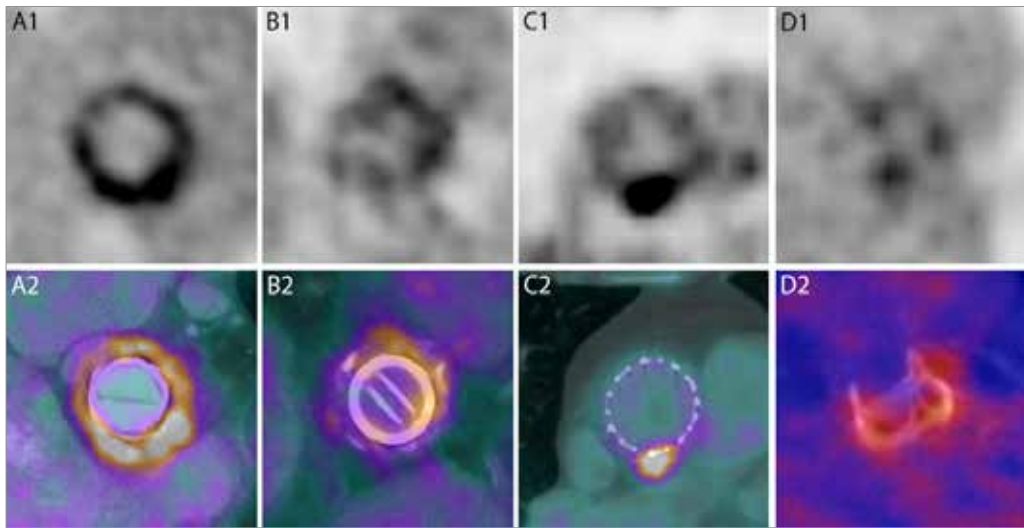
Attenuation-corrected positron emission tomography (top) fused positron emission/computed tomography (A2–C2) and three-dimensional maximum-intensity projection positron emission/computed tomography (D2) images of different patterns and intensities of ^{18}F -FDG uptake around prosthetic heart valves: a surgically confirmed case of prosthetic aortic valve endocarditis in its acute stage showing diffuse and intense uptake (A); a mechanical aortic valve prosthesis infected by *Streptococcus equinus* in a patient that had already been treated with intravenous antibiotics for 14 days showing less intense, semi-circular ^{18}F -FDG uptake (B); a very focal and intense pattern of ^{18}F -FDG uptake in a definite case of a transcatheter-implemented aortic valve endocarditis⁹ (C); and a semi-recently implanted (63 days) bioprosthetic valve showing mild multi-focal uptake of ^{18}F -FDG around the three metallic struts (D).
